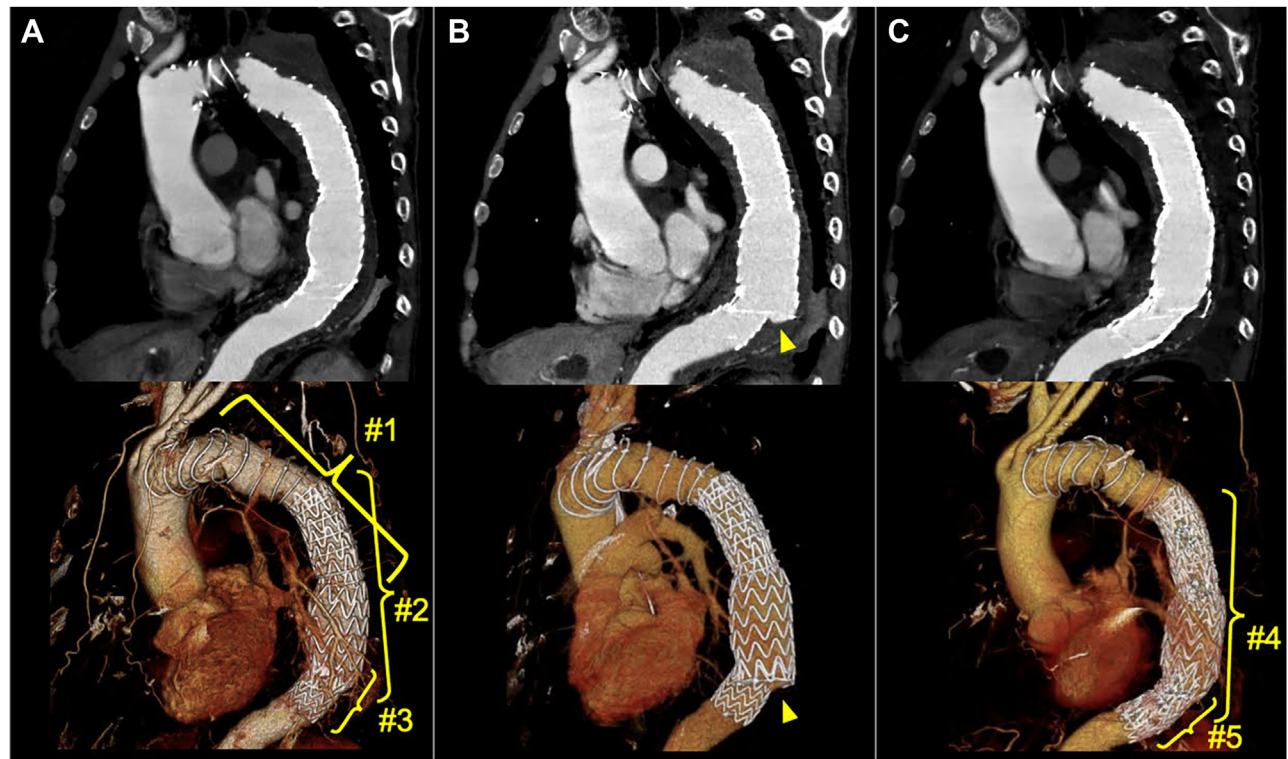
Enhanced computed tomography images of the patient, sagittal view and 3-dimensional reconstruction. (A) At 10 months before the event. (B) Immediately after the trauma. (C) At 10 days after the treatment. Previously inserted stent grafts are indicated (#1, #2, and #3). Migration and disconnection of the stent grafts, stent graft dilation, and blood leakage to the left lung were observed (arrowhead). Additional stent grafts were inserted for repair (#4 and #5).
